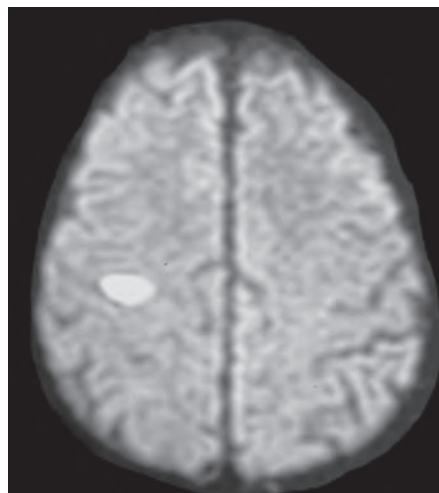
Magnetic resonance imaging of the brain axial diffusion weighted image showing infarct over the right hand knob area
